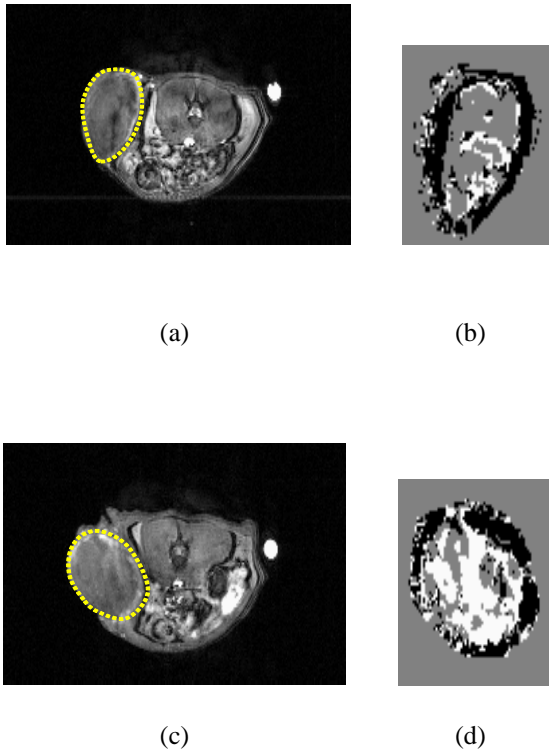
DCE-MRI results: on the left, the MRI images related to two different experiments, with the tumoral zone highlighted. On the right, the resulting segmentations
